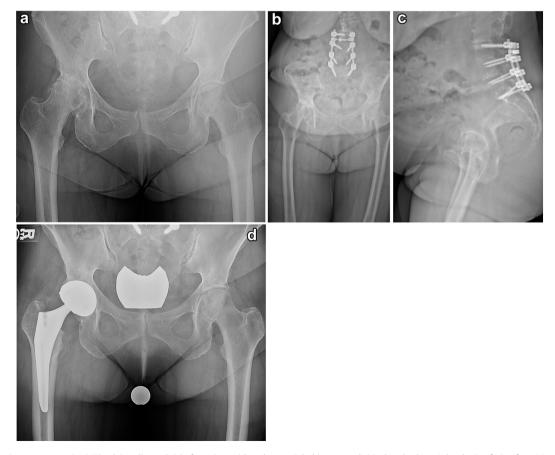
Preoperative anteroposterior (AP) pelvis radiograph (a) of a patient with end-stage right hip osteoarthritis that also has a 3-level spine fusion from L3 to the sacrum (b and c). She underwent a right THA with a dual-mobility articulation (d) and did well at 2-y postoperative follow-up without dislocation.
